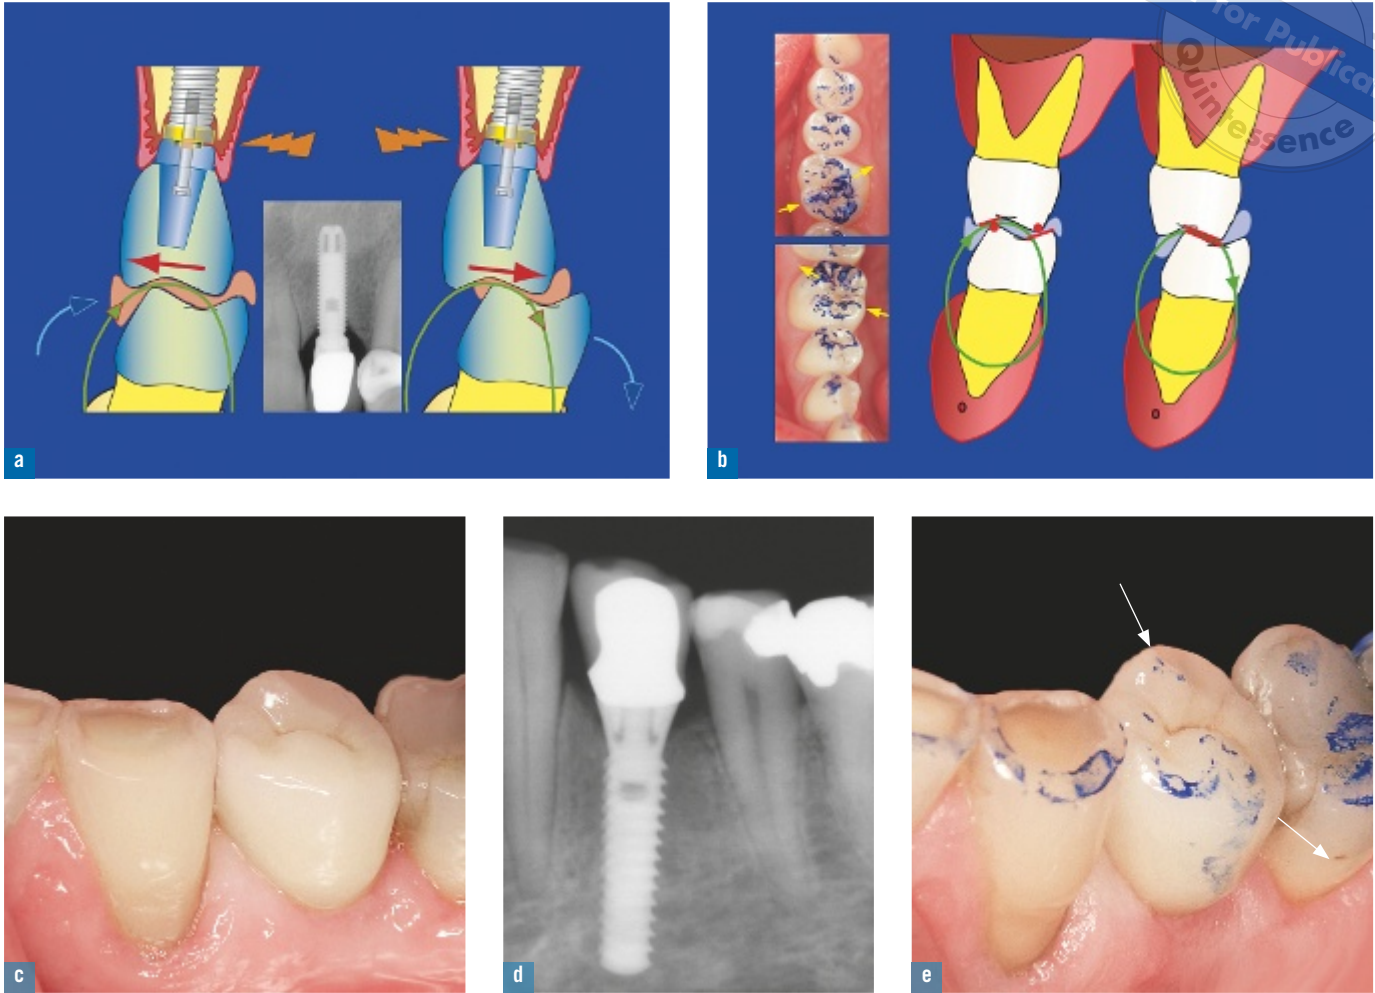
(a) Stress and micromovements on the implant–abutment junction and implant collar will liberate bacterial toxins, induce bone loss, and may accelerate fracturing of the screw. (b) Cycle-in and cycle-out phases of the chewing cycle on the right side. (c) Buccal view of an implant restoration on the left first premolar. (d) Radiograph of the SwissPlus implant supporting the restoration, showing the correct cervical bone level. (e) Occlusal view of the functional masticatory guidance adjustment, with light contact on the implant. (Courtesy of Dr. M. Le Gall, Lorient, France.)
